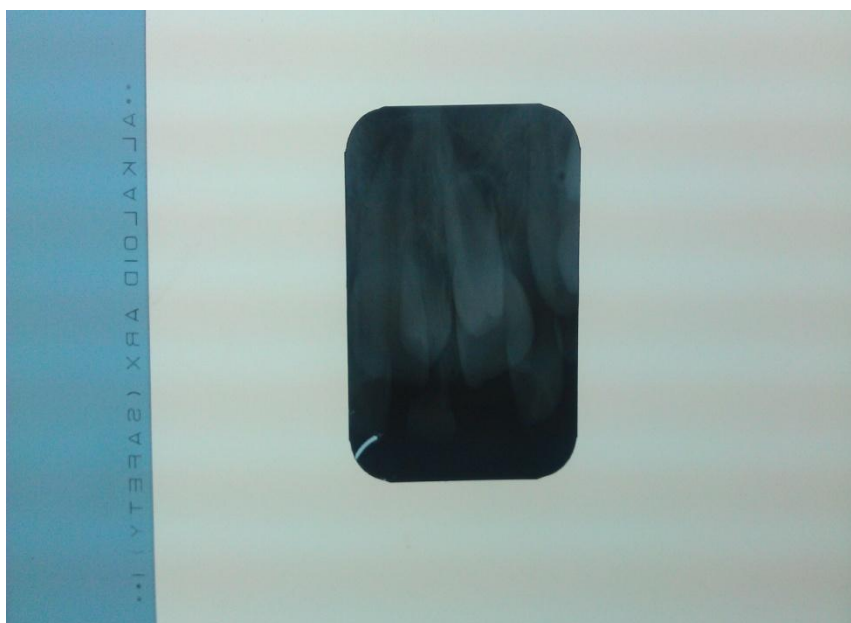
Intraoral periapical radiographic
